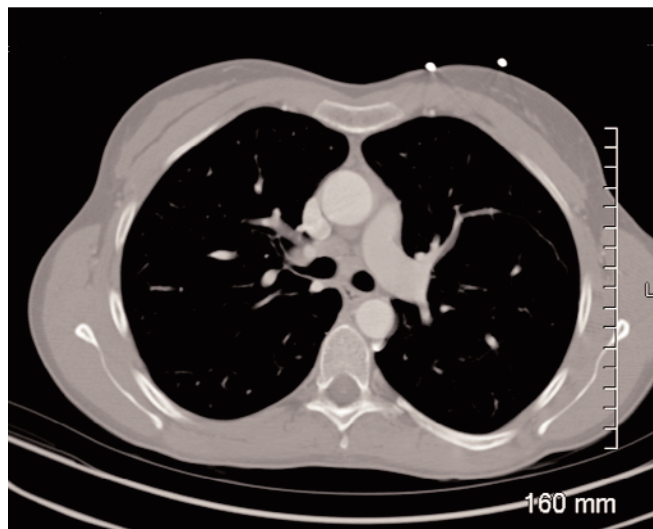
Chest computed tomography scan (mediastinal window) showing mediastinal lymphadenopathy within the anterior tracheal and subcarinal nodal stations.
